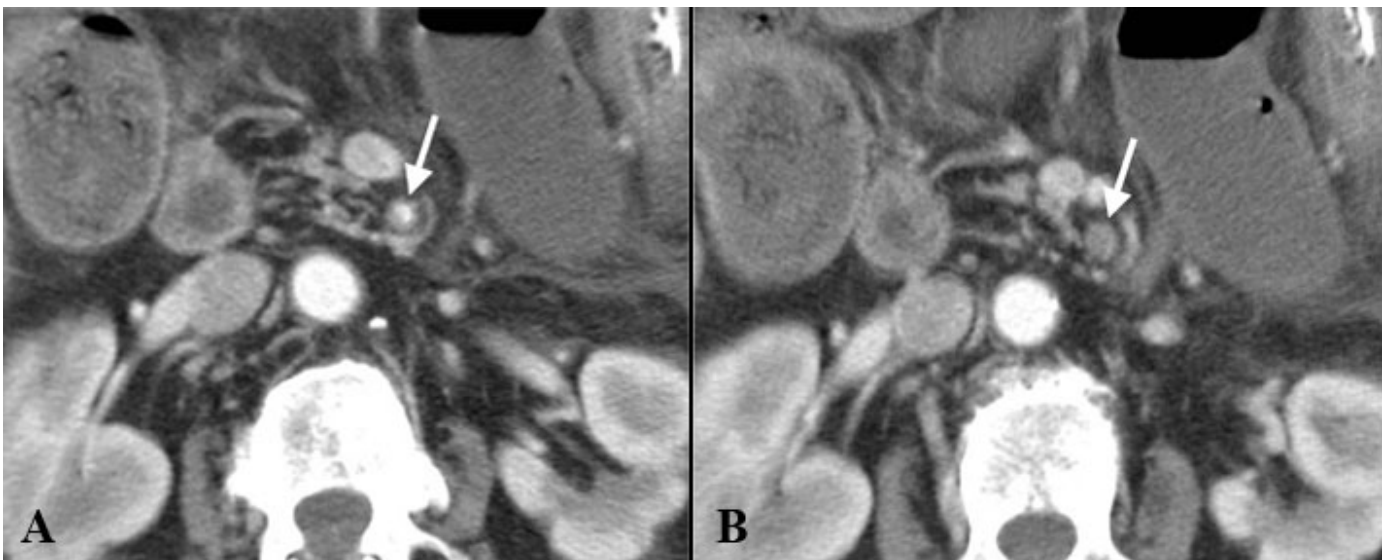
IV contrast-enhanced CT shows the superior mesenteric artery patent (arrow) proximally (A) and occluded (arrow) distally (B) consistent with thrombus.
